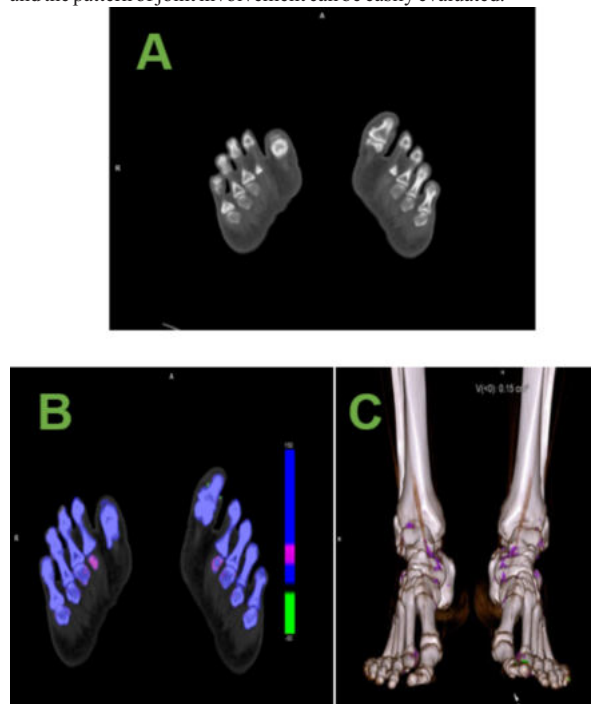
AA negative axial CT with no findings of gout.
